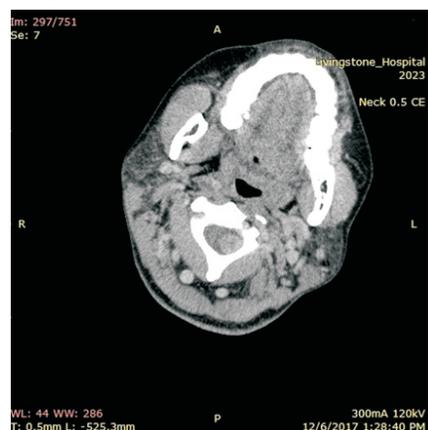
CT image at C2 showing a hyper-dense lesion (blue arrow) compressing the spinal cord on the left.
